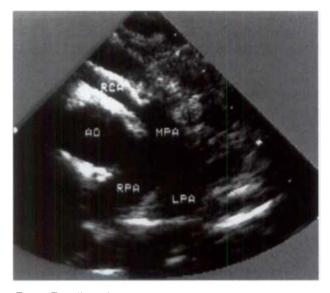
Two-dimensional echocardiographic study, parasternal short axis view: Note the direct communication of the RCA with the MPA. Ao = aorta, RCA = right coronary artery, MPA = main pulmonary artery, RPA = right pulmonary artery, LPA = left pulmonary artery.
